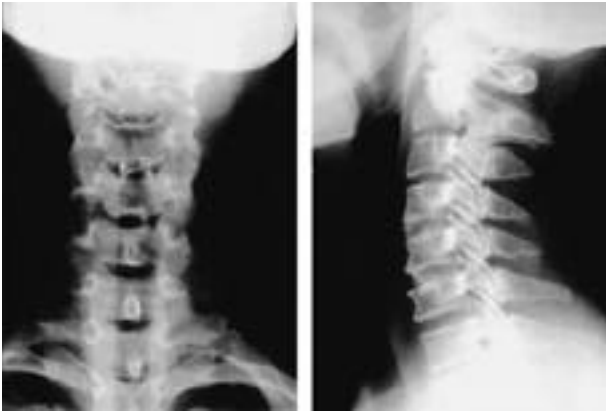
Anteroposterior and lateral roentgenograms of C4-5 and C5-6 fusion with autogenous bone graft.
